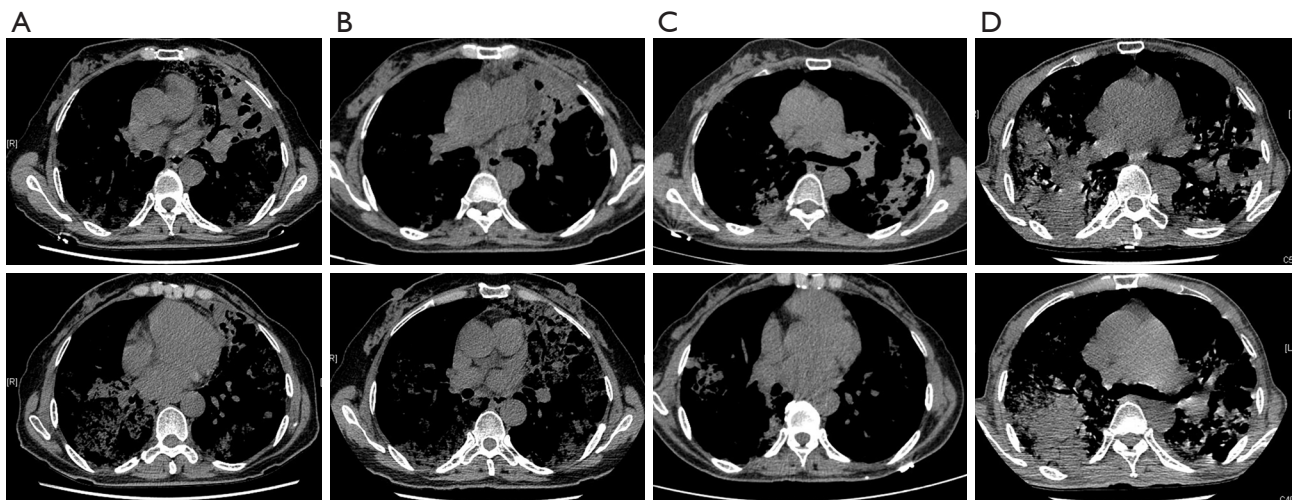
Computed tomography images showing response to afatinib treatment. (A) Pretreatment of afatinib in September 2018; (B) after 1 month of treatment with afatinib; (C) after 12 months of treatment with afatinib; (D) after 22 months of treatment with afatinib.
